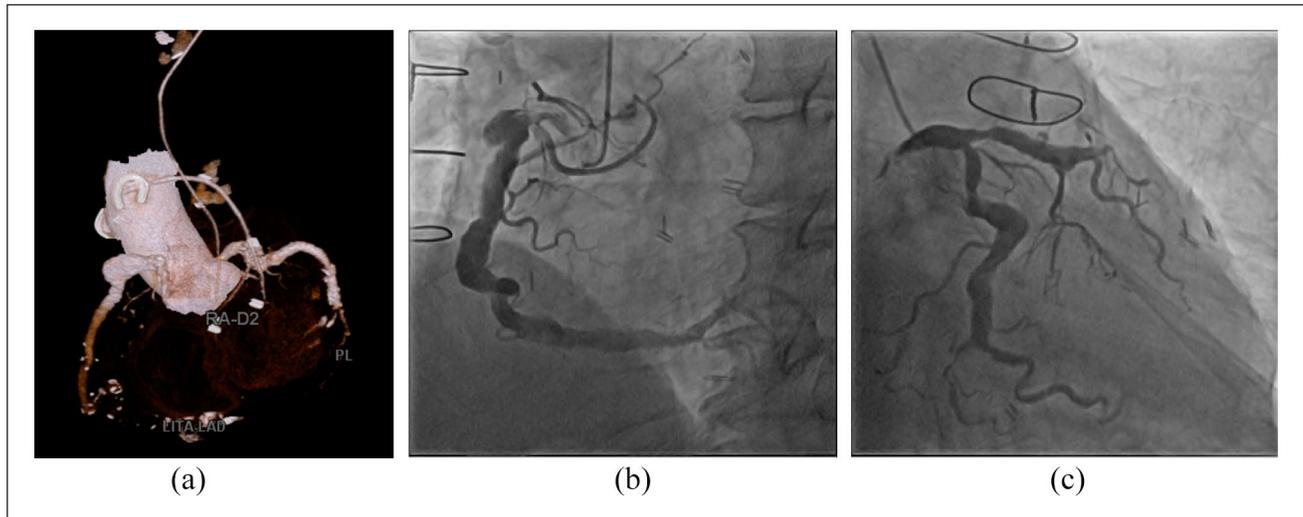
The situation immediately after the first surgery. (a) A three-dimensionally reconstructed computed tomographic image of the native coronary artery and bypass grafts. (b) Coronary angiography reveals a slightly dilated right coronary artery and (c) a left circumflex artery.
